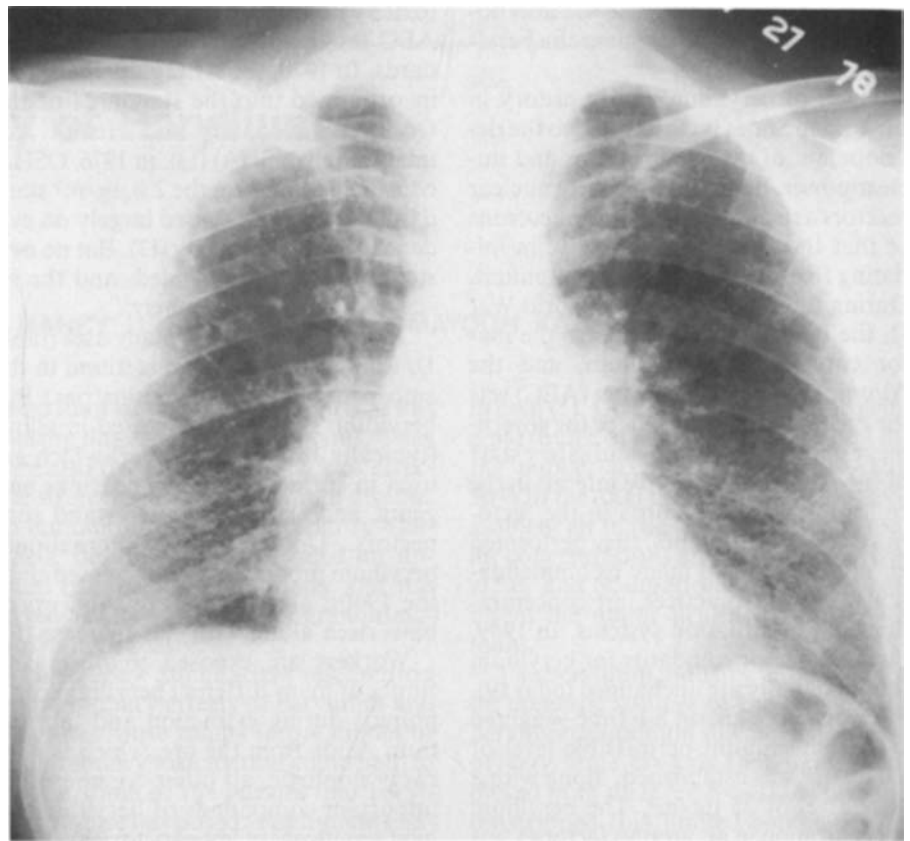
Chest radiograph from patient with chronic beryllium disease showing irregular opacities in all lung zones, enlarged hilus, and cardiac enlargement. The profusion was classified as s/s, 2/2 in the ILO 1980 classification system.
